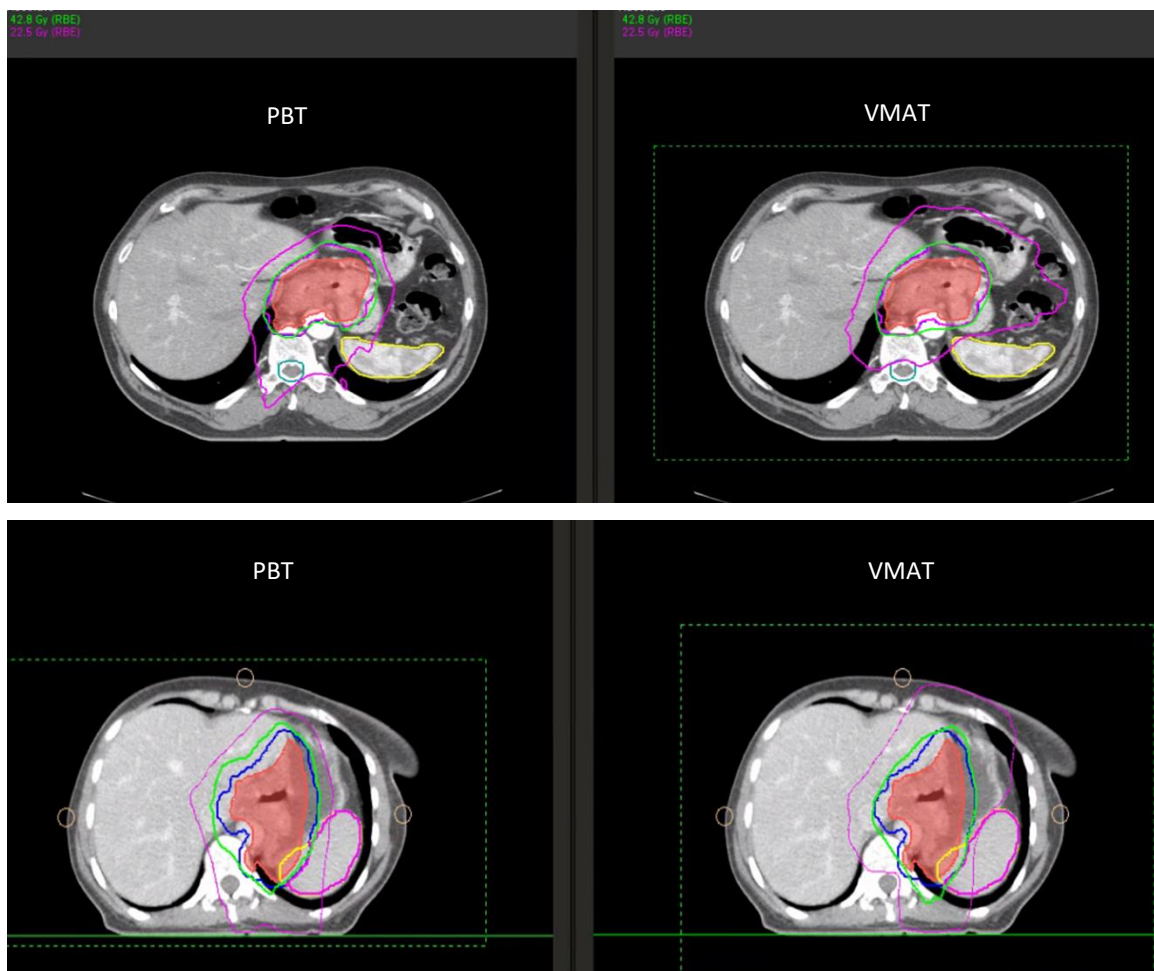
Axial CT slices around the level of the gastro-oesophageal junction for two separate cases. Spleen is outlined in both cases. PBT plan is on the LEFT, VMAT plan is on the RIGHT. GREEN - 95% isodose; PURPLE - 50% isodose.
